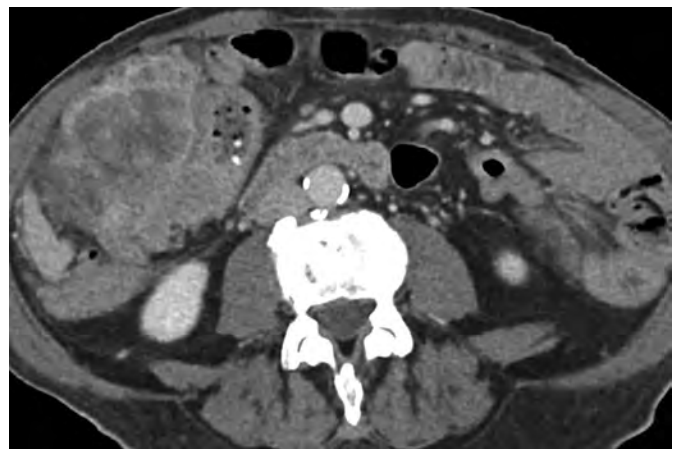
Computed tomography (CT) showing neoplasia of the cecum/ileocecal valve region with transmural infiltration.
